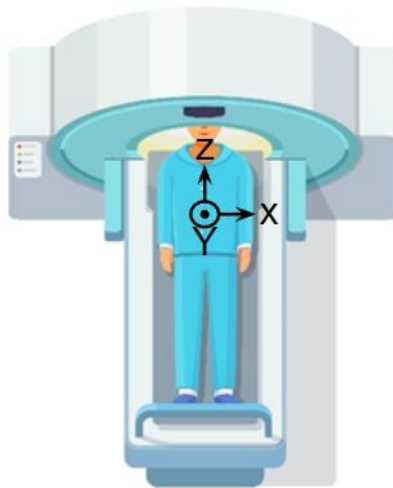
MRI scanner and coordinate system.
